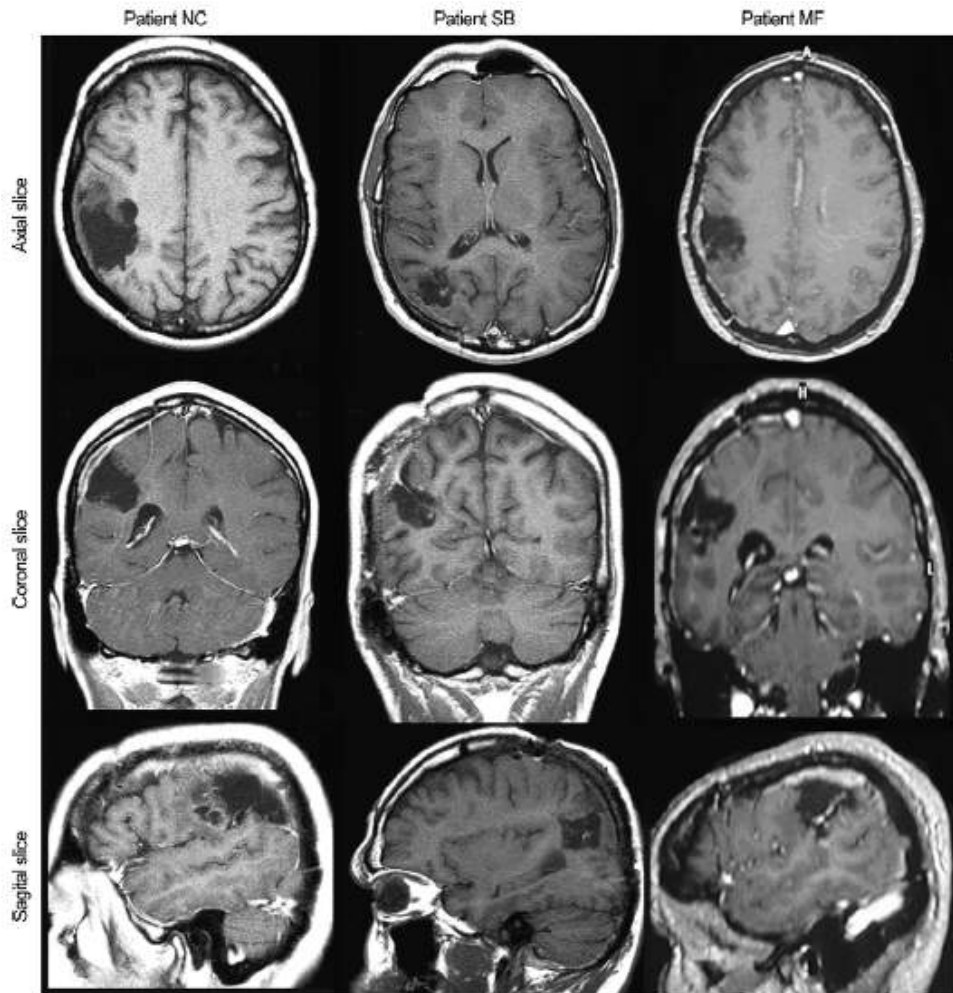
Post-operative anatomical MRI of the patients confirms the resection of right IPL in the three patients.
